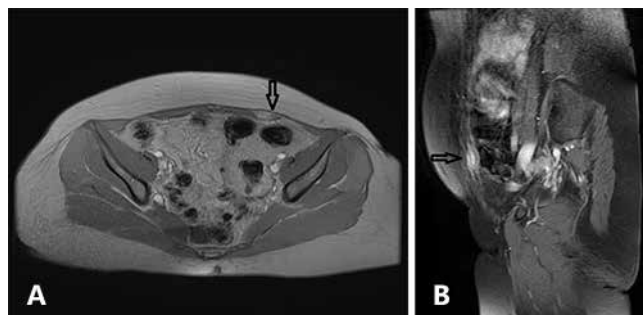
Arrows show the area of endometriosis in rectus abdominis muscle: A) CT scan in transverse section; B) CT scan in sagittal section
